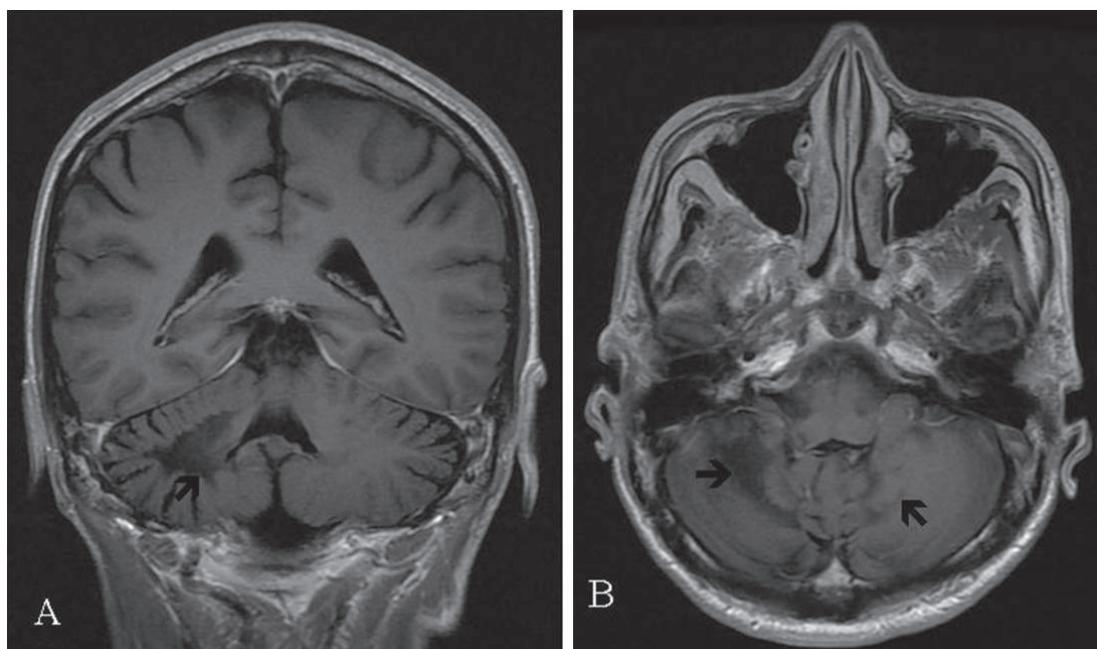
MRI (3T) examination performed 5 weeks post HAART therapy, (A) Coronal post Gadolinium T1-weighted image (TR/TE 2783ms/8.472ms), (B) Axial post Gadolinium T1-weighted image (TR/TE 2943ms/8.48 ms). Arrows showing non enhancing low signal intensity lesions in both the cerebellar hemispheres.
